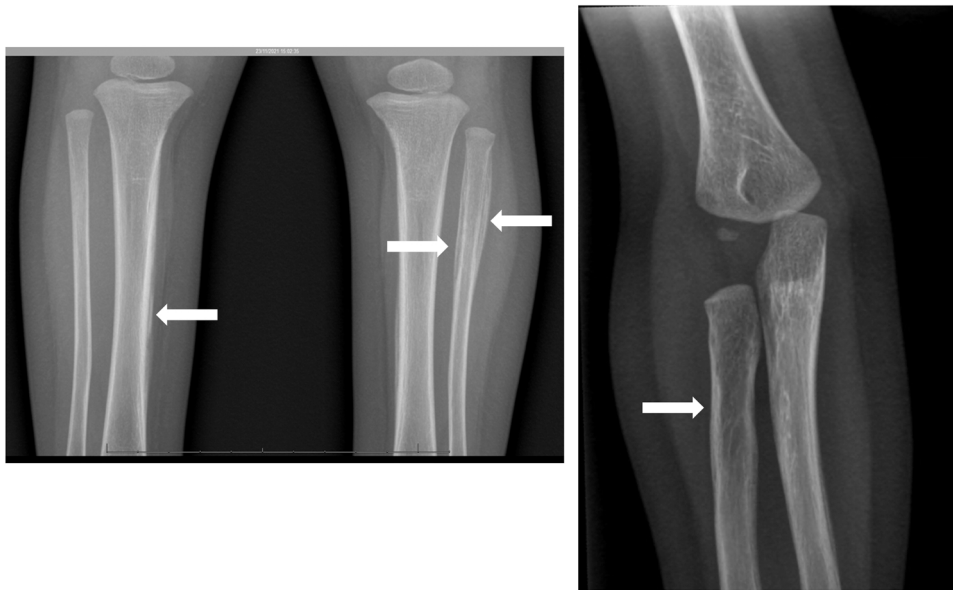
X-ray of long bones. X-ray of lower limbs with arrows showing multiple periosteal appositions, alternating radiolucent and radiodense metaphyseal lines, and osteolytic lesions.
